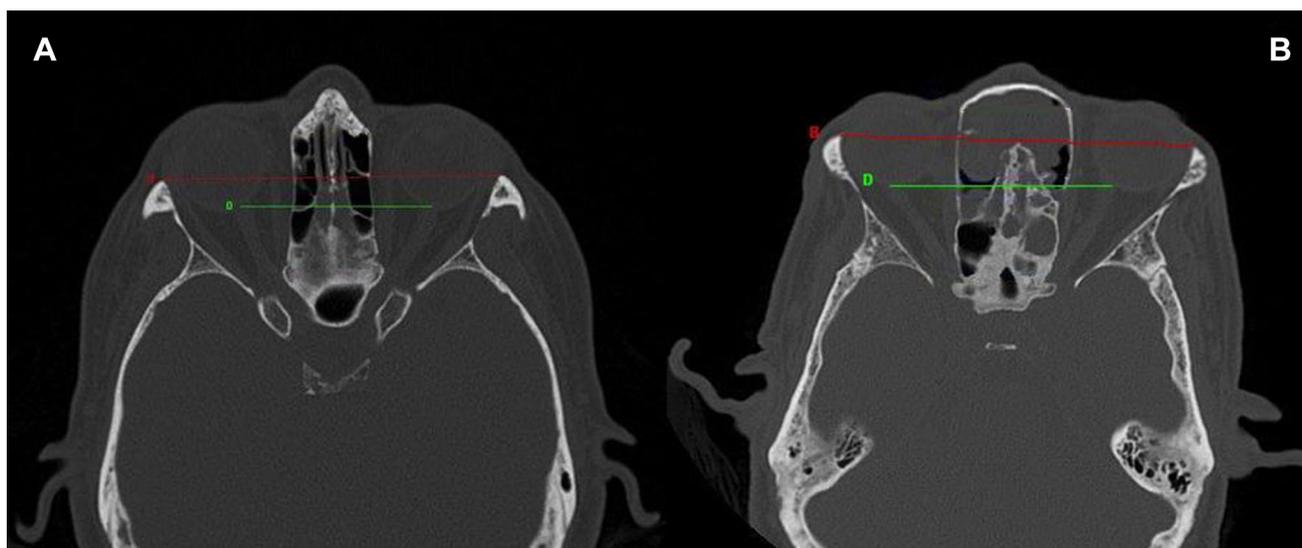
Interoptic and interzygomatic distances measured in CT scans of nasal polyposis patients and healthy controls
